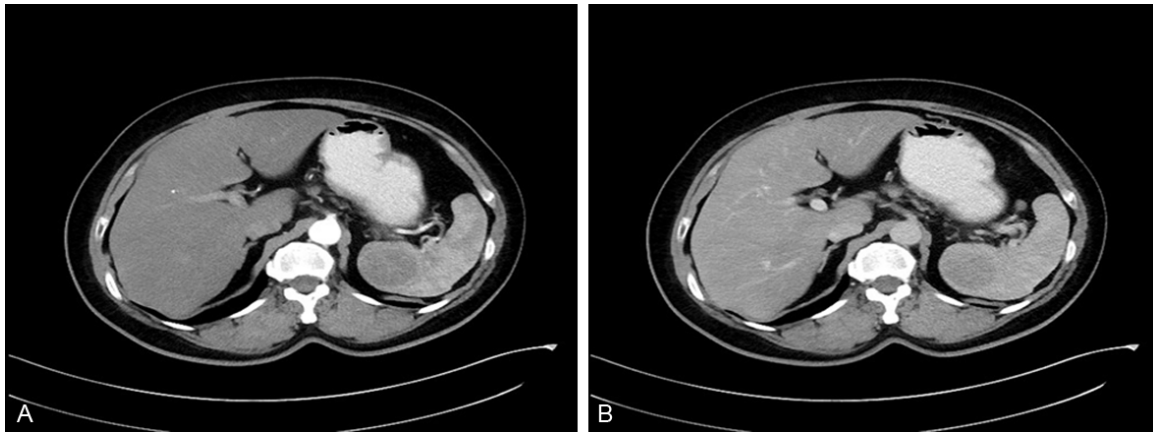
Contrast-enhanced computed tomography (CT) of the abdomen revealed a splenic mass lesion. A. A low-density mass in the arterial phase of CT scan. B. A low-density mass in the venous phase of CT scan.
